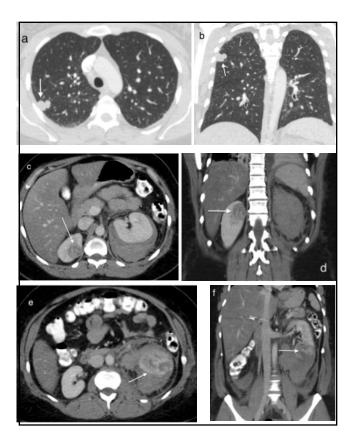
Diagnostic CT scan of the chest (a, b) revealed a bilobed right-upper-lobe pulmonary lesion measuring 1.4 cm AP x 2.1 cm TV x 1.8 cm CC. Lungs are the most common site of metastasis for choriocarcinoma, accounting for 76%-87% of metastases, and it is rare to have additional metastatic sites in the absence of lung metastases. CT scan of the abdomen also demonstrated bilateral contrastenhancing renal lesions measuring 2.7 cm AP x 2.6 cm TV x 3.5 cm CC in the right upper pole (c, d) and 2.7 cm AP x 2.4 cm TV x 4.2 cm CC in the left lower pole (e, f). The left renal lesion was also associated with a large retroperitoneal hematoma measuring approximately 22 cm in CC dimension. Choriocarcinoma is a hypervascular tumor and is often associated with bleeding; as a result, biopsy of metastatic lesions is not routinely performed, as it may result in excessive bleeding.
